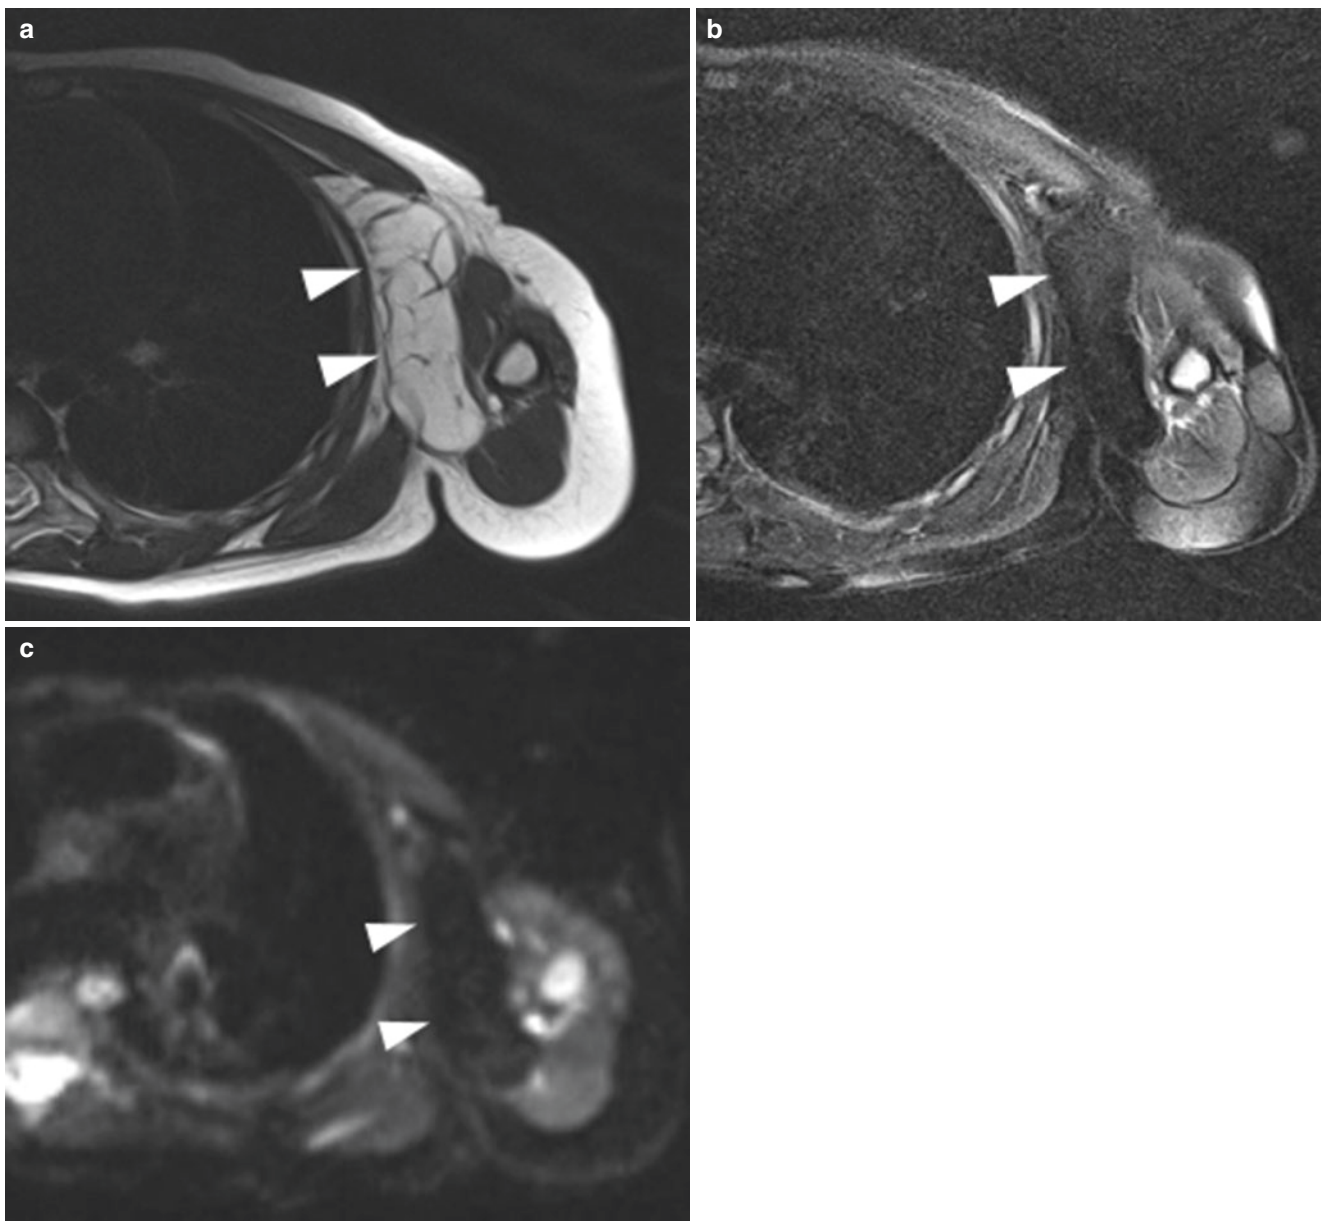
A teenage boy with chest wall lipoma. (a) Axial T1-weighted BLADE MR image demonstrates a hyperintense multiseptated well-circumscribed mass (arrowheads) located in the left chest-wall. (b) Axial T2-weighted BLADE MR image with fat suppression shows a
